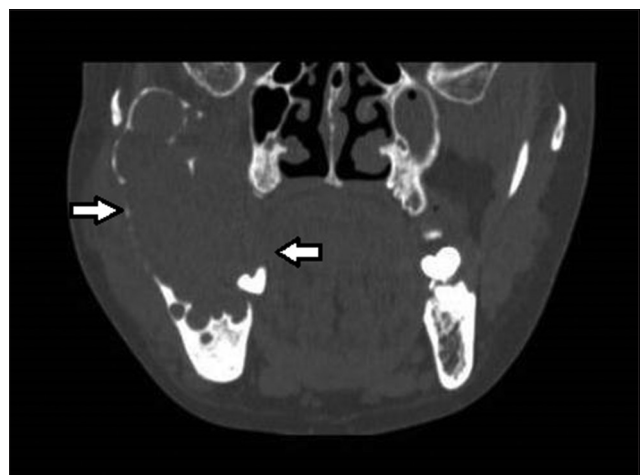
Computed tomography coronal view showing multiple locules on the right side of the mandible with expansion and thinning of both buccal and lingual cortical plates
